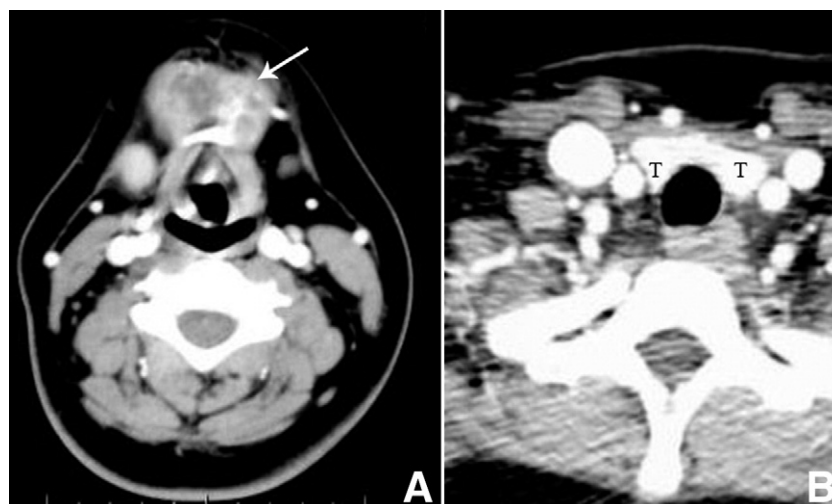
An 18-year-old patient with persistent, slowly enlarging midline neck mass. (A) Axial CT reveals a heterogenous multicystic and solid midline mass at the level of the hyoid bone (arrow) cephalad to and separate from a normal appearing thyroid gland (B, area T). Excisional biopsy confirmed papillary thyroid carcinoma arising in a thyroglossal duct cyst. It is important to avoid administration of iodinated contrast in the CT evaluation of a patient with suspected thyroid carcinoma as its administration precludes the subsequent use of I-131 or I-123 in complete staging evaluation following total thyroidectomy for a minimum of 12 weeks.
